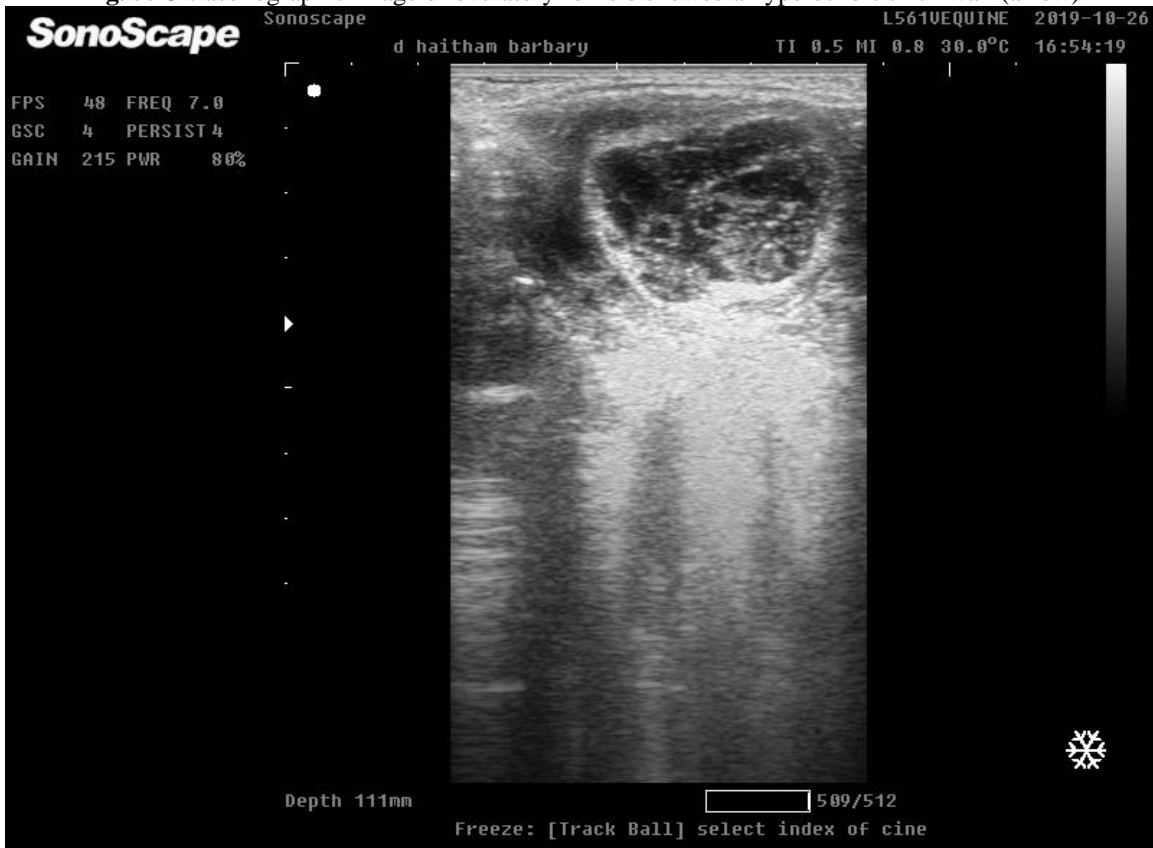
Ultrasonographic image of corpus hemorrhagicum 48 hours following ovulation
